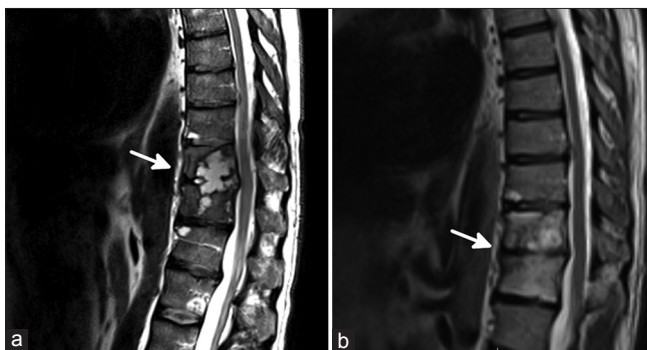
Sagittal magnetic resonance imaging reconstructions show T11/12 spinal coccidioidomycosis (arrow) at the presentation (a) and 3 months after medical management (b)
